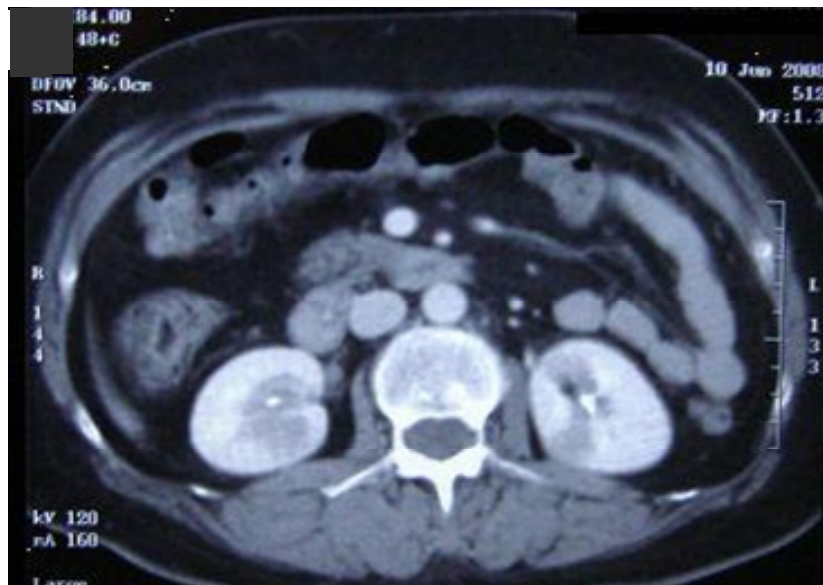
CT scan of the abdomen showed left and right kidneys localisations.
